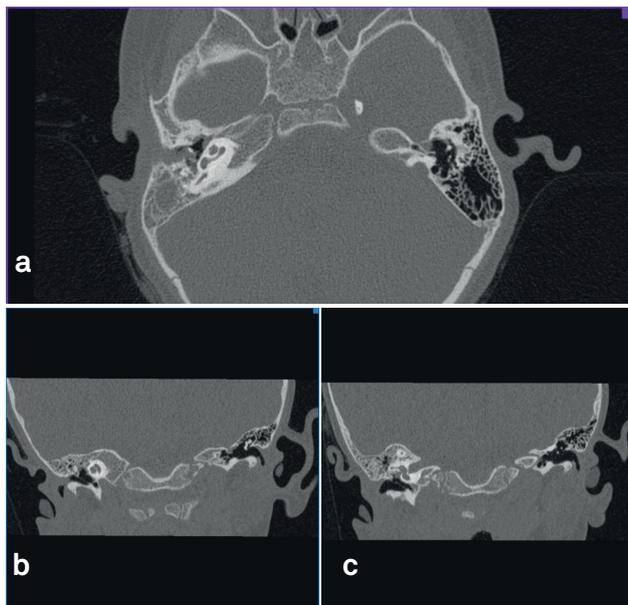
Cochlea, vestibule and semi-circular canals are not monitored in the left ear on the axial (a) and coronal reformatted MPR (b and c) images in CT scan of the temporal bone.
